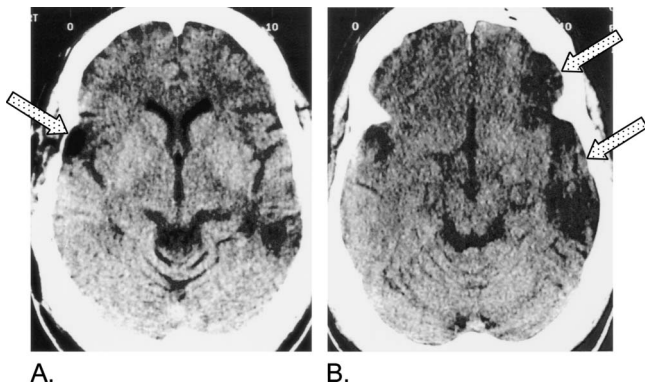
Brain computed tomography scan of patient RP, showing atrophy of the right temporal pole (A) and extensive encephalomalacia in the left inferior frontal and temporal areas (B) (arrows).
